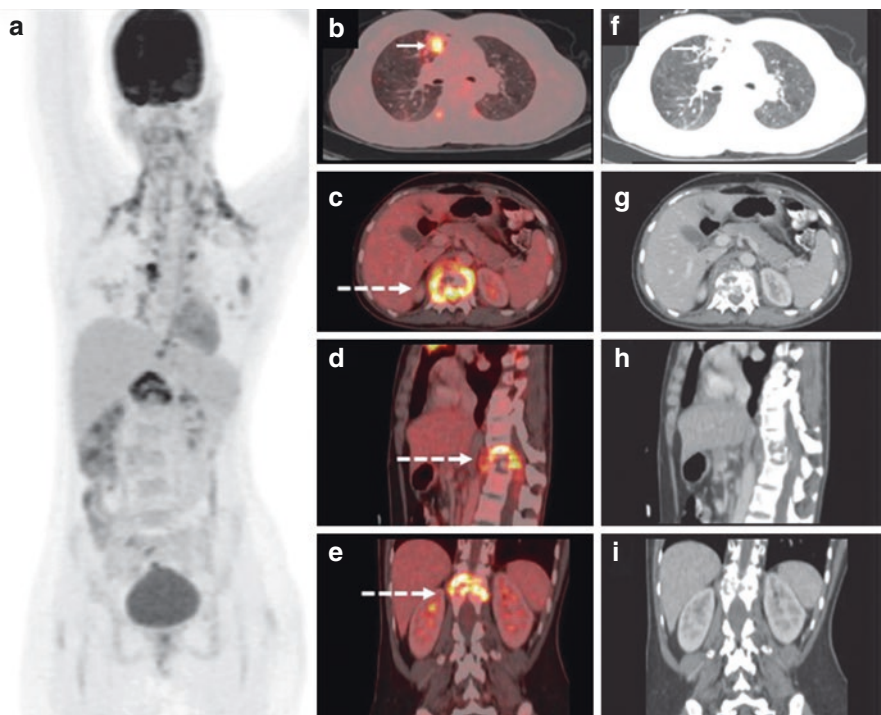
Twenty-eight-year-old woman with a history of treated pulmonary TB 5 years back now presented with back pain for two months. MRI of the thoracolumbar spine revealed the pathological collapse of the D12 vertebra. The patient underwent 18F-FDG PET/CT to look for the activity and pattern of the disease. Maximum Projection Image (MIP) (a), PET/CT fused (b, c, d, e), and CT only (f, g, h, i) images show FDG uptake in a fibro-consolidatory change in the anterior segment of the RUL and parenchymal nodules (b, f, arrow). Intense FDG uptake is noted in the collapsed body of the D12 vertebra with contiguous involvement of the adjacent D11 and L1 vertebral discs with pre and paravertebral collection—cold abscess (c, d, e, dashed arrow)
